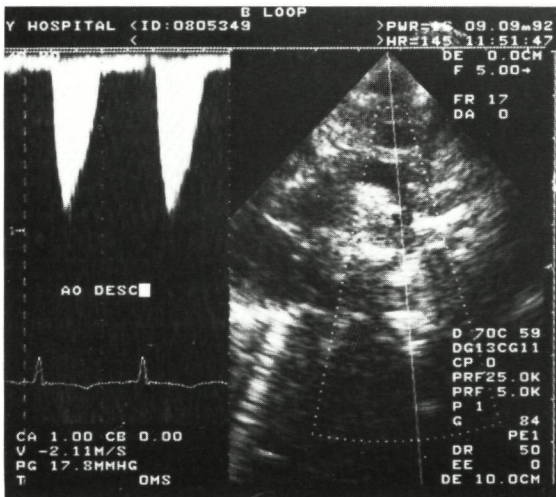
Echocardiographic image of the aorta after decannulation
